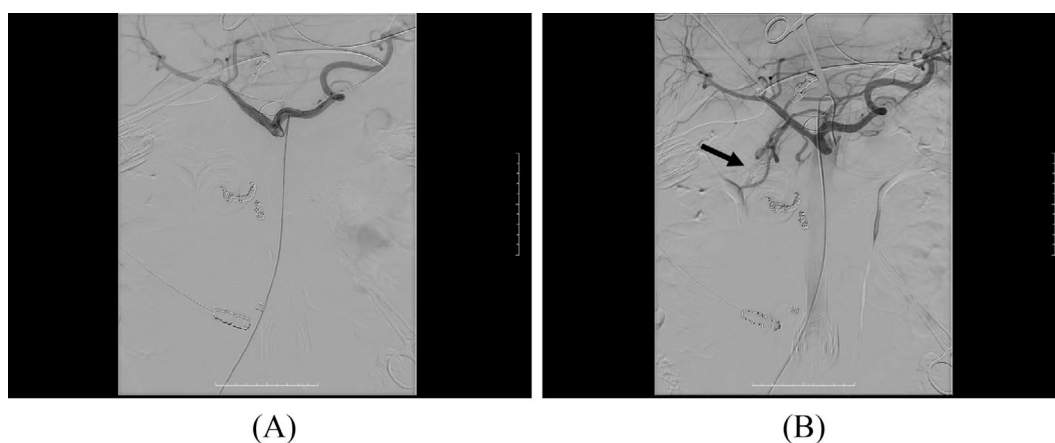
(A-E) Contrast-enhanced computed tomography and an angiogram on current admission (approximately four years after the initial episode and admission).
